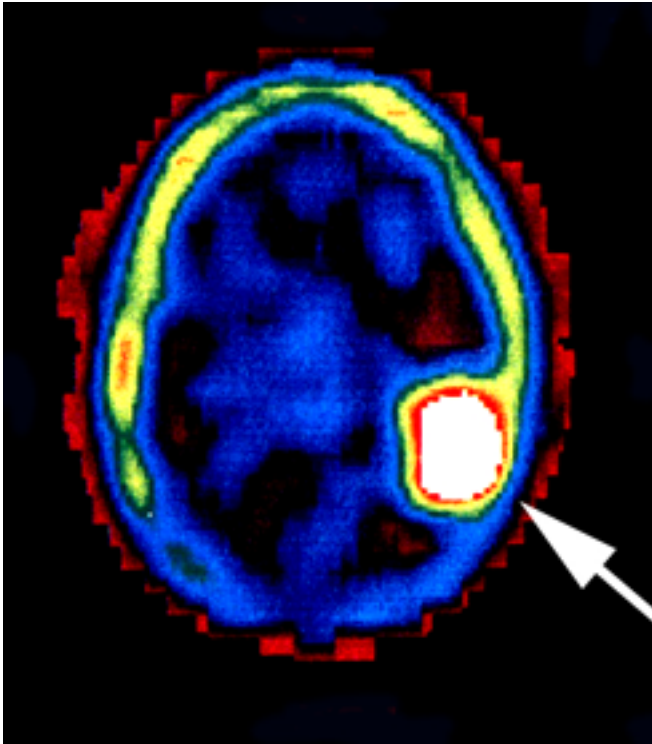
A thallium SPECT of a patient with a left parietal weakly enhancing lesion. The scan demonstrates intense uptake of Thallium-201, indicating a hypermetabolic lesion (arrow) proven during operation to be an anaplastic astrocytoma.
